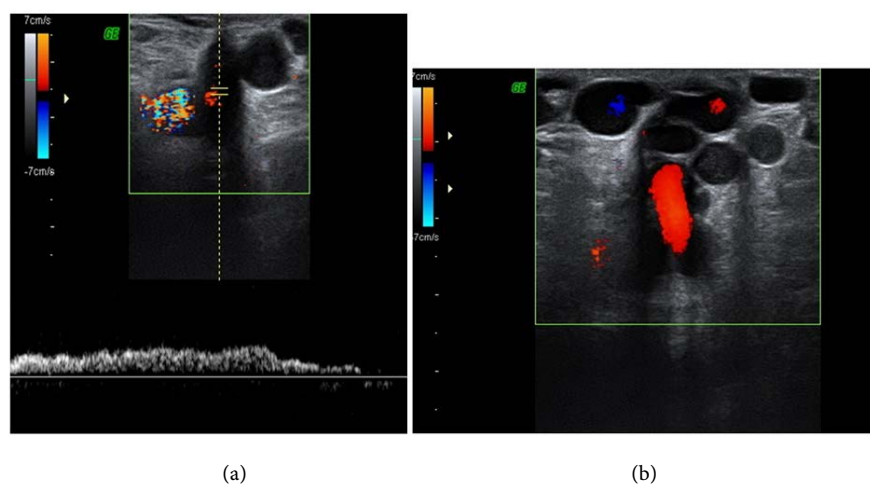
(a) Duplex ultrasound image after Valsalva at injection site demonstrates venous Doppler pattern; (b) Color Doppler ultrasound images after Valsalva maneuver from injection site demonstrates deep to superficial direction of flow, note engorged varicose packets also.
